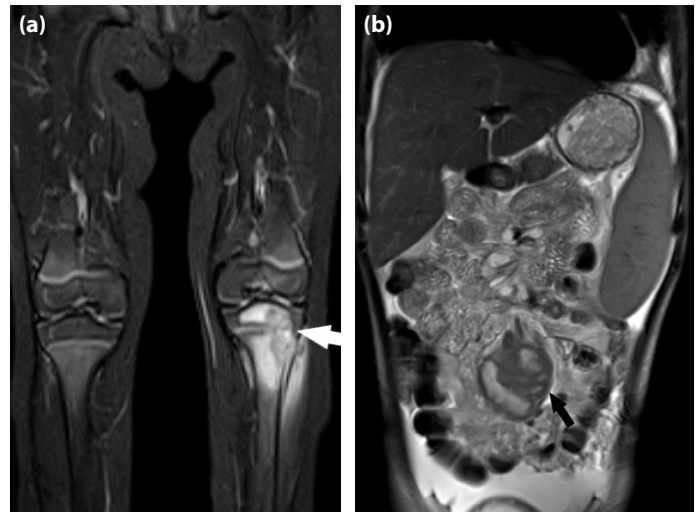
(a) 18-month-old girl with TB osteomyelitis. T2-weighted, fat-suppressed coronal extremity MRI shows high signal intensity in the proximal metaphysis and epiphysis of the tibia, indicating transphyseal spread (arrow). (b) 17-year-old boy with abdominal TB. T2-weighted coronal abdomen MRI displays enlarged, clustered lymph nodes with central necrosis (arrow), as well as ascites, indicative of peritoneal involvement.
